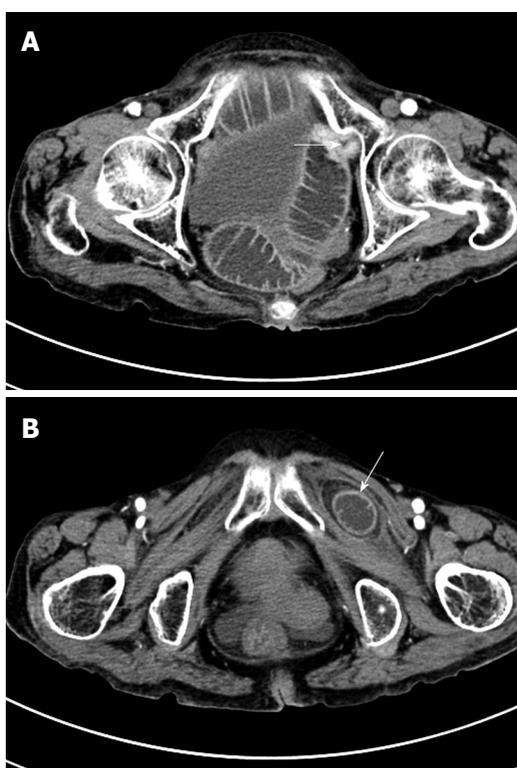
Abdominal axial CT image. A: Severe dilated small bowel and abrupt stenosis at the terminal ileum in the pelvic cavity (arrow); B: A low-density mass with clear border located between the pectineus and the left external obturator muscles (arrow).
